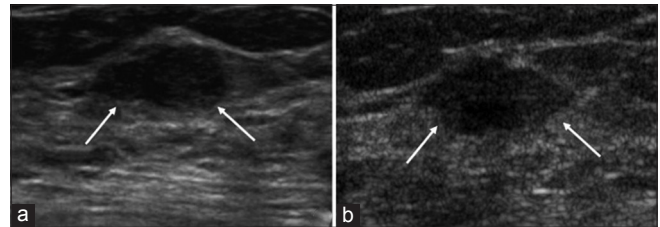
A 45-year-old woman with a mass detected on the screening breast ultrasound (US) in the right breast, upper outer quadrant. (a) Initial US image showed a 1.2 cm oval circumscribed isoechoic mass in the right upper outer quadrant, corresponding to category 3 (arrows). (b) On the 12-month follow-up US, the margin of the mass changed into more microlobulated and indistinct and was assessed as category 4 (arrows). US-guided core needle biopsy was performed and fibroadenoma was confirmed.^[3]
